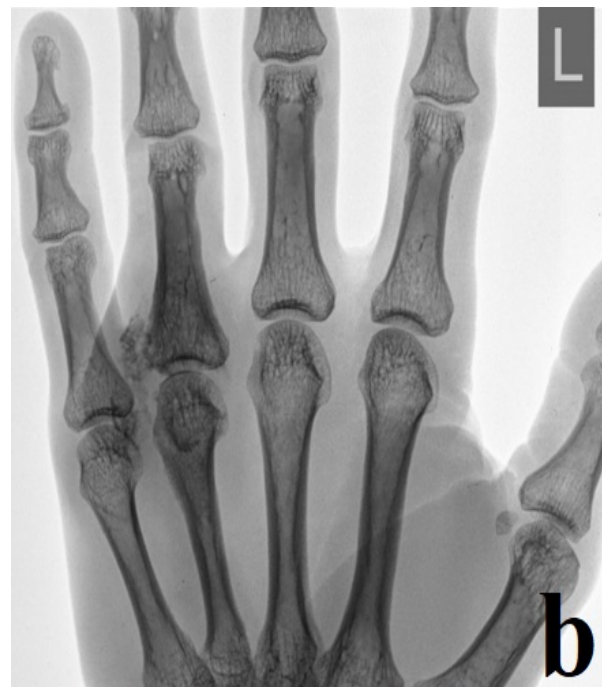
x-rays in direct projections*
